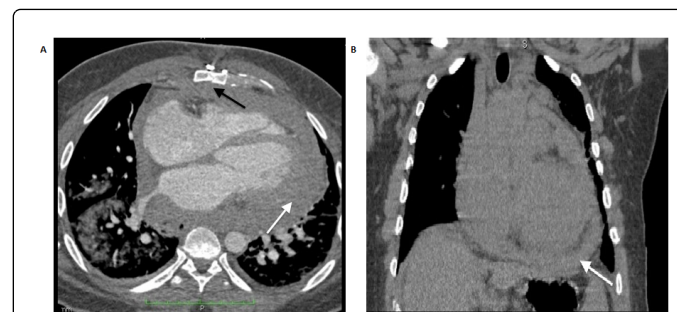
Axial and coronal chest CT images respectively. The axial image demonstrates the diffuse, thickened pericardium and associated effusion (white arrow), despite the patient's previous sternotomy (black arrow). This finding is also readily identified on the coronal image. A visible pericardial mass was not identified on either section.
